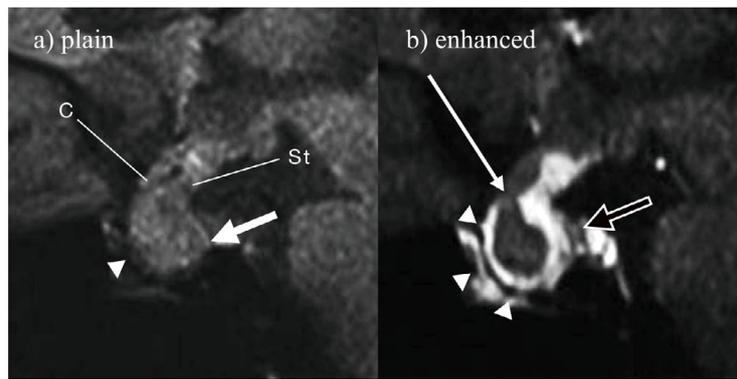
MR image in acute phase (postpartum day 10)
